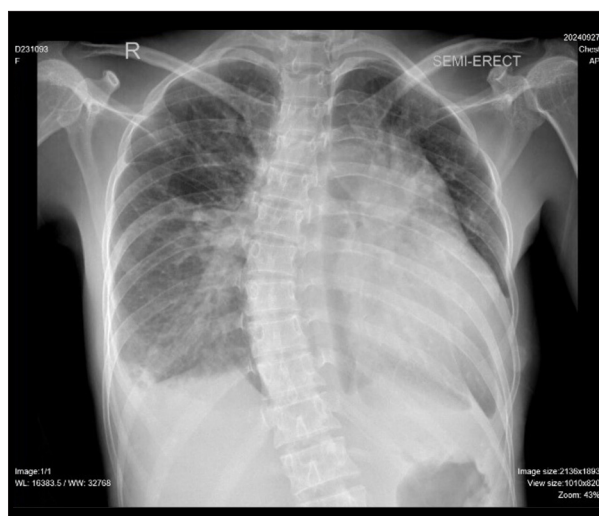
Chest Radiograph. Chest X-ray demonstrating cardiomegaly, pleural effusion, pulmonary edema, and vascular congestion.
